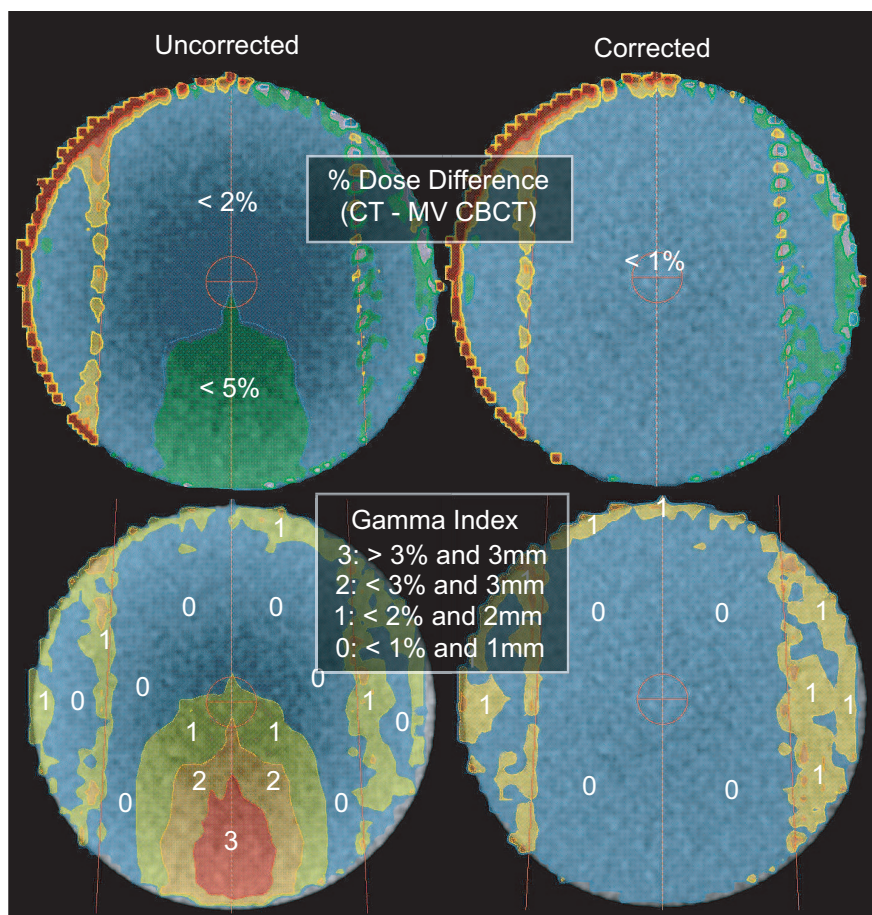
Dose percentage differences (CT - MVCBCT) (top) and gamma indices (bottom) for the head-size water cylinder uncorrected (left) and corrected (right) for uniformity.
